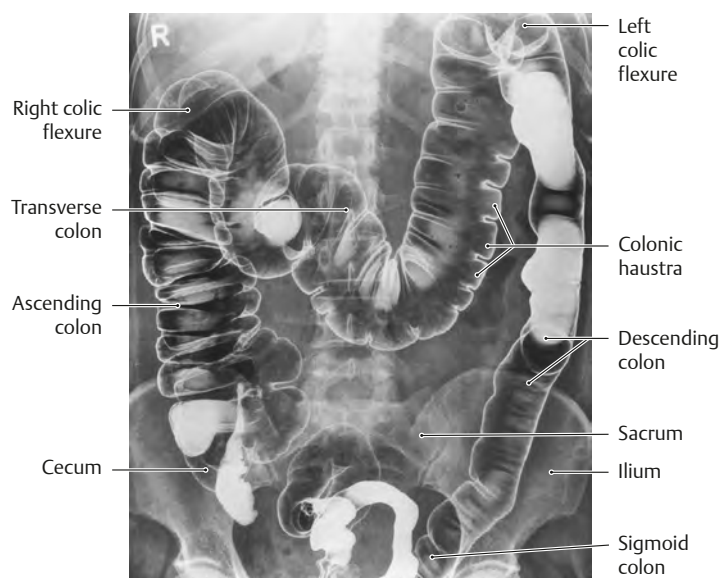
Radiographs of double contrast barium enema.
